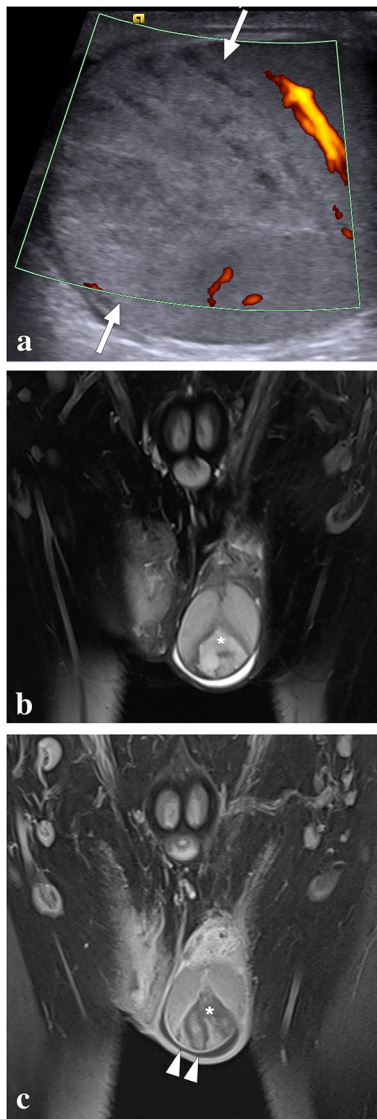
A 32-year-old male with known Behcet's disease presented to the ER with acute scrotal pain. There was no history of trauma. a On power mode Doppler US, a triangular-shaped heterogeneous hyper-echoic lesion with no apparent vascularity is seen (arrows). b Coronal T2W fat-suppressed MR image shows a triangular heterogeneous hyperintense lesion (asterisk) with the apex pointing towards the testicular mediastinum and surrounded by a T2 hypointense rim. Mild reactive hydrocele is also noted. c Coronal postcontrast T1W fat-suppressed MR image demonstrates the hypoenhancing lesion (asterisk) with sharp borders and peripheral rim enhancement (arrowheads). Imaging findings were consistent with segmental testicular infarction, likely related to Behcet's disease. The patient was placed on supportive treatment, to which he responded well
